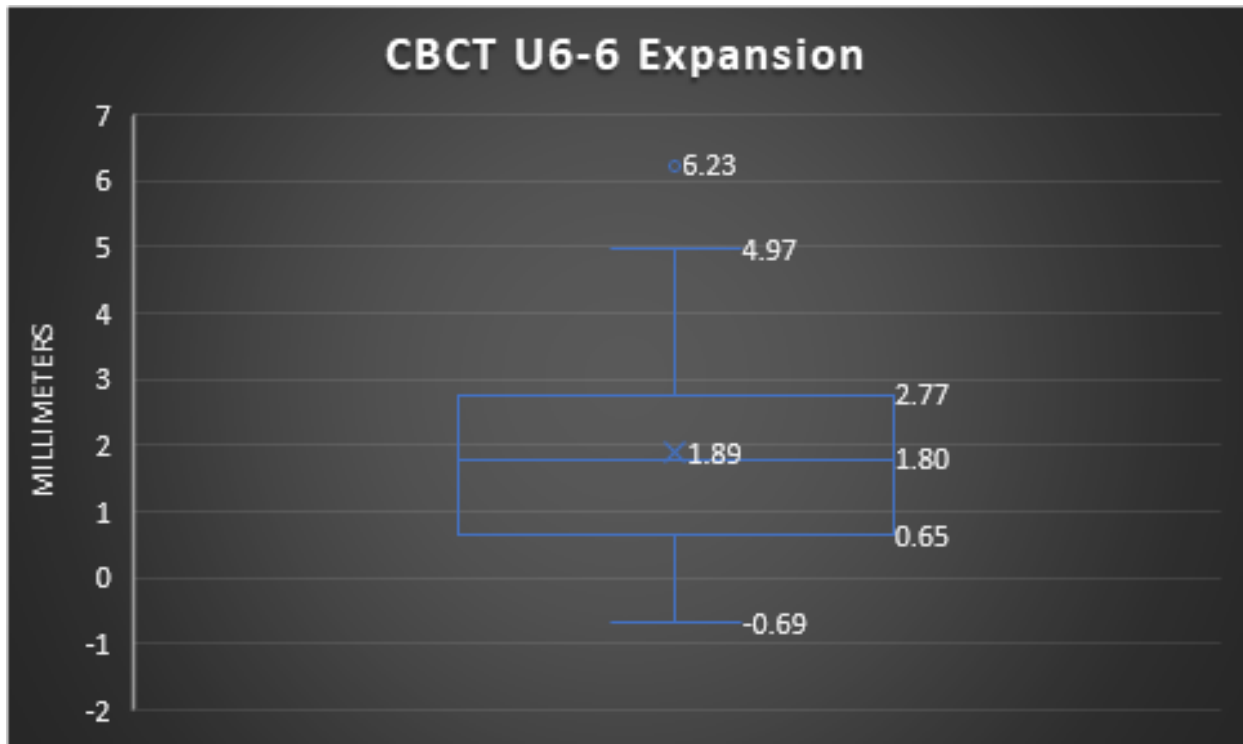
(Maxillary Molar Expansion shown by CBCT)
